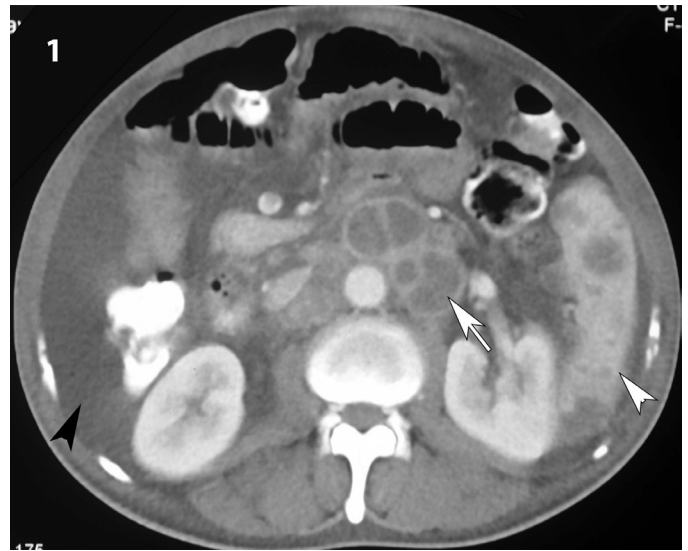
Contrast-enhanced computed tomography abdomen showing multiple confluent necrotic abdominal lymph nodes (white-arrow), multiple splenic granulomas (white arrow head), and ascites (black arrow head).
